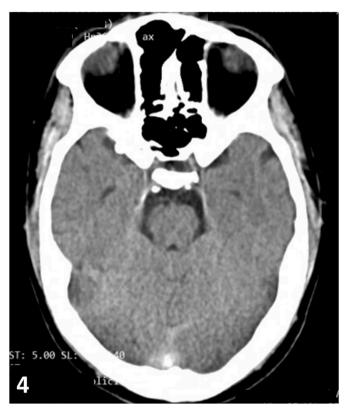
Axial non- enhanced Computed Tomography Scan done at the time of discharge shows normal study of the brain.
